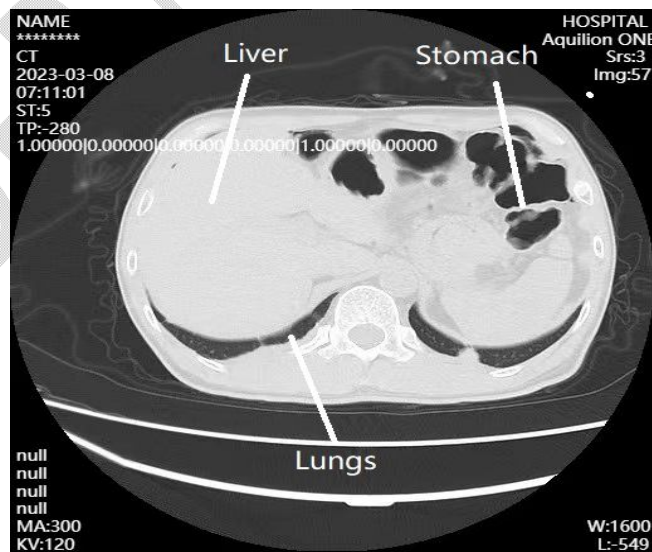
Chest CT 13 days after operation
